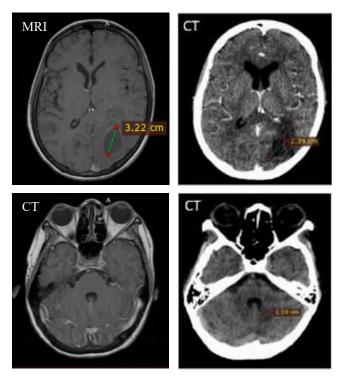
MRI images (left) from the initial examination and subsequent evaluation using a CT scan with contrast (right) revealed a slight reduction in the diameter of the previously identified lesion in the left occipital lobe. Additionally, a new lesion with a diameter of 1.19 cm was observed in the left cerebellum, indicating further progression of the condition.
